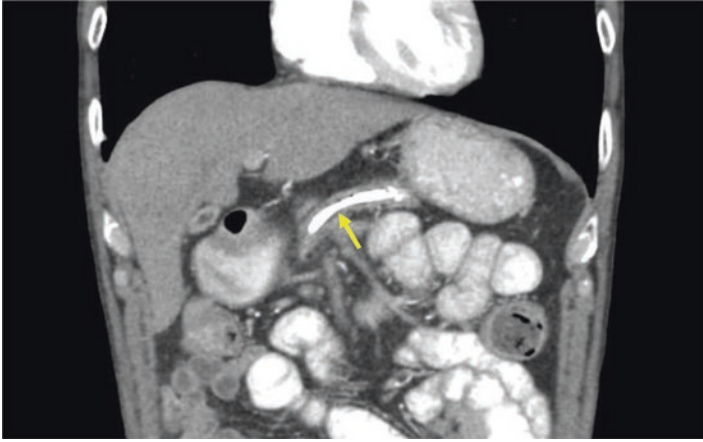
Coronal CT image with entirely intraductal pancreatic duct stent (arrow)
